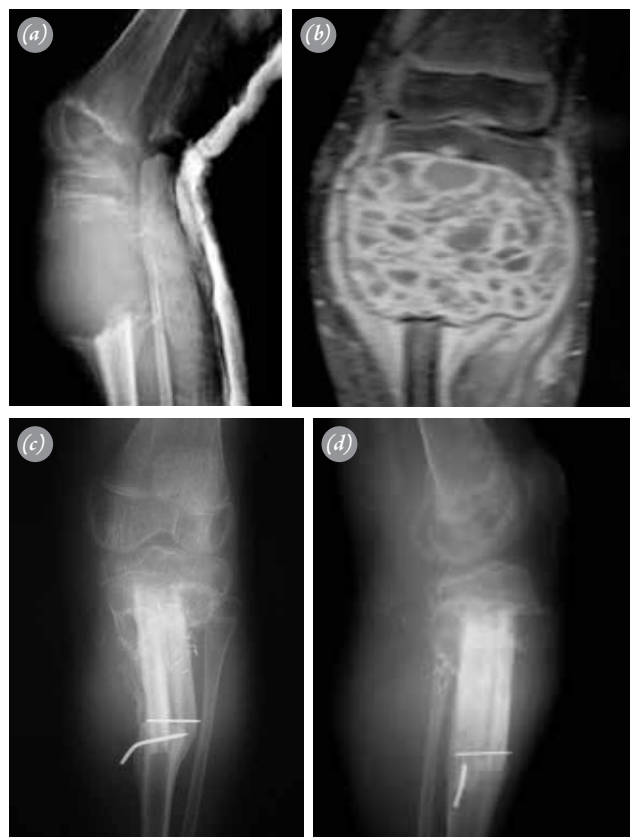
(a) Lateral radiograph of a large-sized mass in the proximal left tibia in a 12-year-old boy. (b) Magnetic resonance image of the same lesion. (c) Anteroposterior radiograph taken 6 months after resection of the cyst and reconstruction with fibular autograft. (d) Lateral radiograph taken at the follow-up examination.
